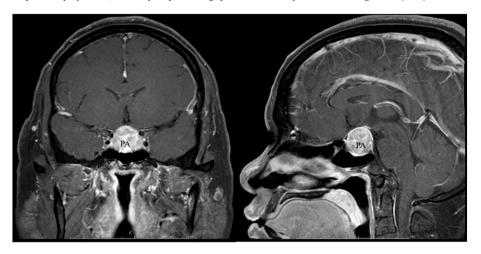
Magnetic resonance imaging (MRI) scan of the patient, five years ago, before his first transsphenoidal surgery (TSS). Preoperative, gadolinium-enhanced T1-weighted scans, coronal and sagittal views, show a pituitary adenoma (PA) at sellar-suprasellar region with optic chiasm compression.
